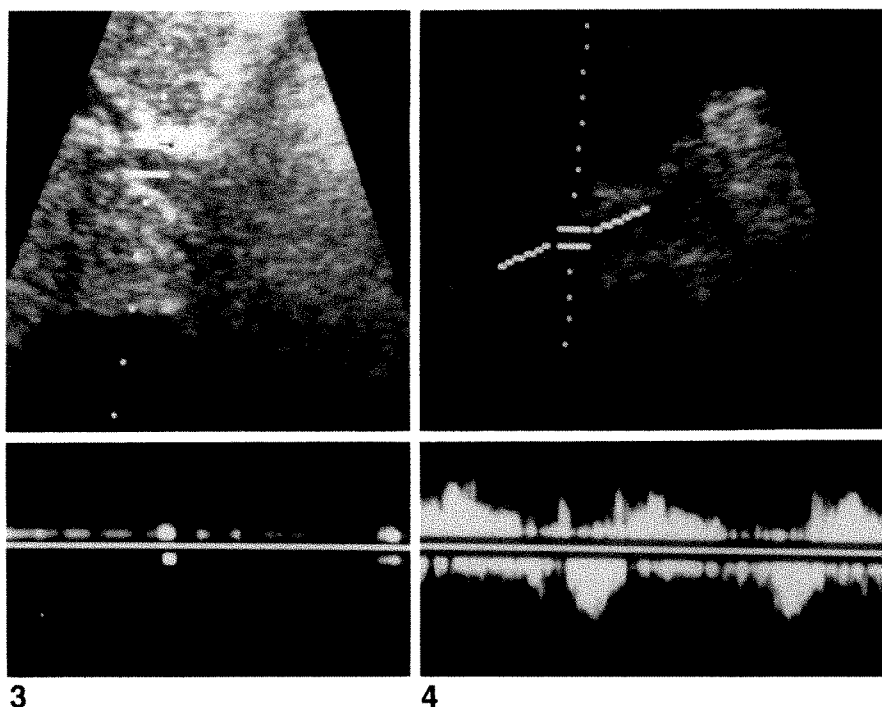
Longitudinal sonogram of thrombosed main portal vein shows no detectable flow and only random noise in this highly amplified duplex Doppler image. Distal splenorenal shunt was patent.
